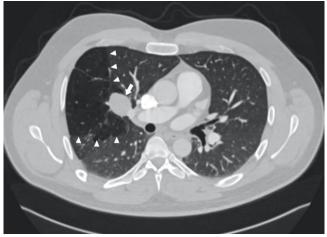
Axial CT image in parenchymal window showing the dilated atretic bronchus plugged with mucus (Arrow) and a radiolucent area due to air trapping and oligemia in the adjacent lung parenchyma (arrowheads)
